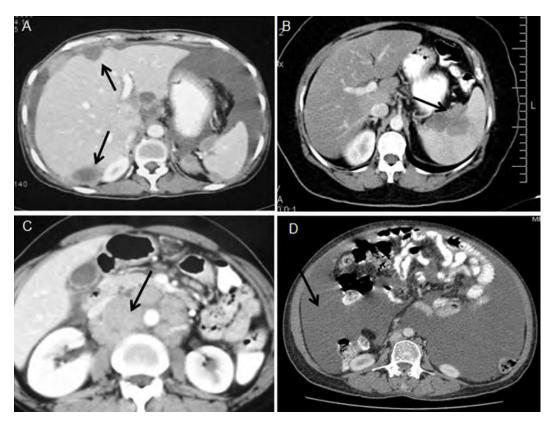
Contrast enhanced CT scans in advanced ovarian disease. A) Multiple liver surface deposits causing scalloping of the surface; B) Splenic hilar deposits; C) Multiple enhancing metastatic retroperitoneal nodes; D) Severe Ascites
